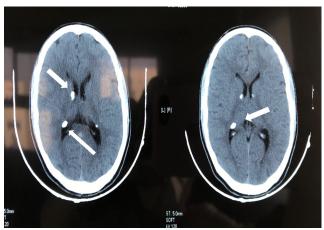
Brain CT scan without injection showing cortical tubers with calcified appearance (arrows).
